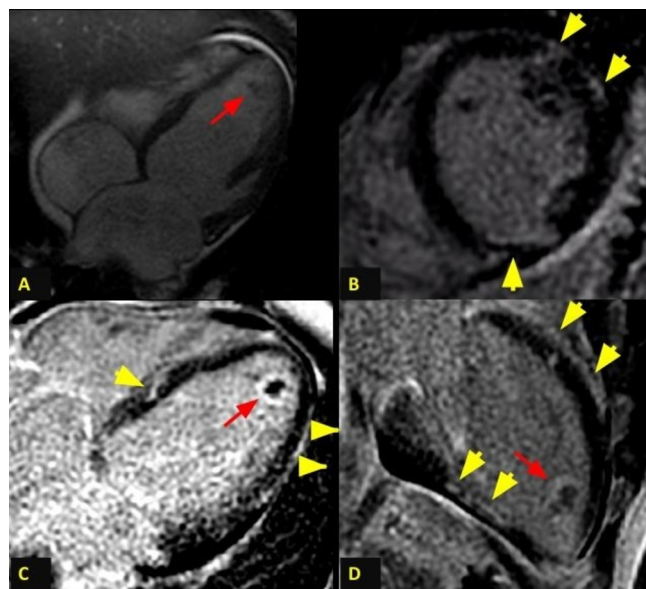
Four chamber cardiac MRI cine (A) with small pericardial effusion and left ventricular apical thrombus (red arrow). Late gadolinium enhancement short axis (B), four chamber (C) and two chamber (D) view demonstrating subendocardial enhancement (yellow arrows) in the midinferior segment and subepicardial enhancement (yellow arrows) in the basal to midanterior, basal anteroseptal and midanterolateral segment. There was no acute oedema indicating chronic process. Early gadolinium enhancement was abnormal. Two of three MRI criteria for myocarditis were met.⁶
